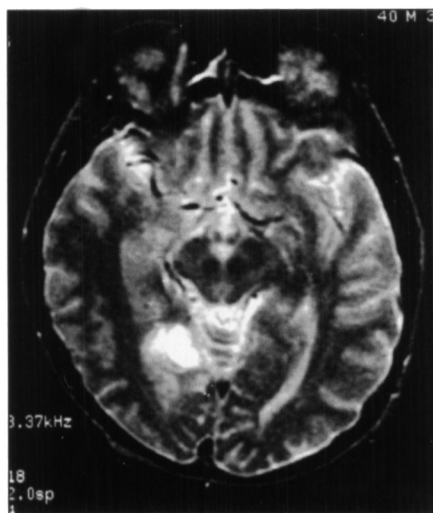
MRI scan of the brain showing an area of cortical dysplasia in the inferomedial portion of the right occipital lobe.
